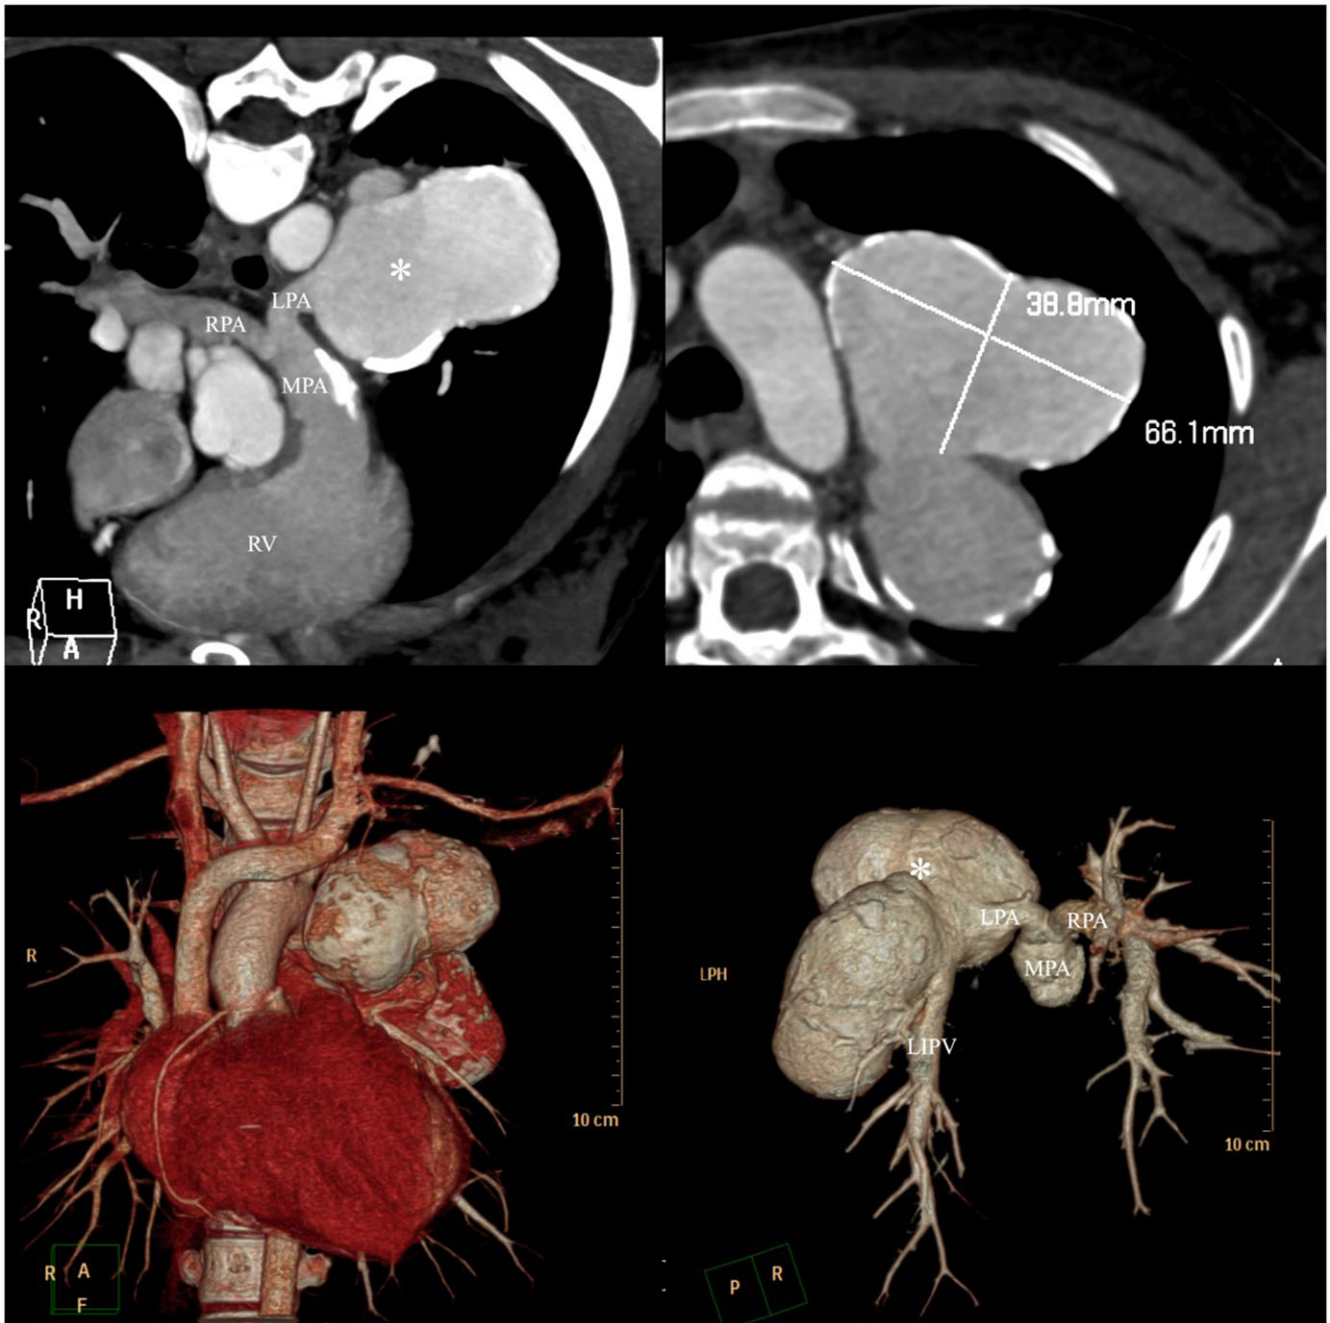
Contrast-enhanced CT scan reveals mild narrowing of the lumen in the proximal left and right pulmonary arteries. Additionally, there are two large cystic aneurysms with multiple calcifications detected in the wall of the left upper pulmonary artery.
